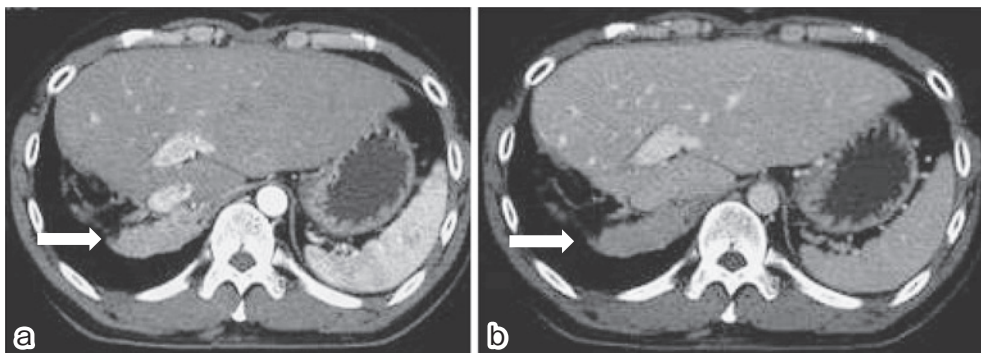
An abdominal contrast-enhanced computed tomographic scan, showing a mass extending from the right side of the diaphragm to the retroperitoneal space. The mass was enhanced in the early phase (a) (arrow) and washed out in the late phase (b) (arrow).
